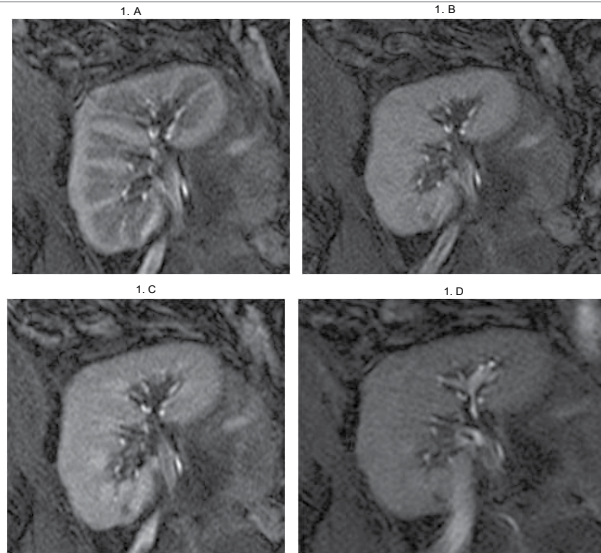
A case of dynamic contrast MRI in normal kidney transplant using coronal GRE T1-weighted sequence shows contrast transition from cortex to medulla with time; (a) early post- contrast scan shows enhancing cortex, (b) after one minute the contrast is equal in cortex and medulla, (c) later on the medulla is more hyper intense than cortex and at delayed image after 5 minutes the contrast excreted into calyces (d).
